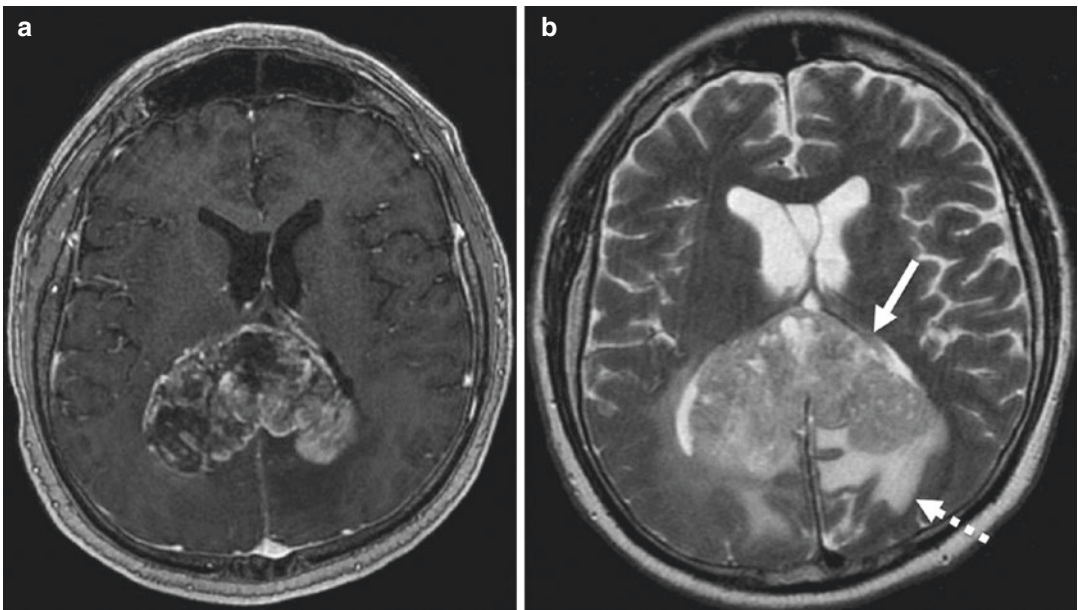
Glioblastoma (GBM). (a) Post-contrast T1-weighted image demonstrates avid heterogeneous enhancement with a “butterfly” pattern crossing the splenium of the corpus callosum. (b) T2-weighted image
